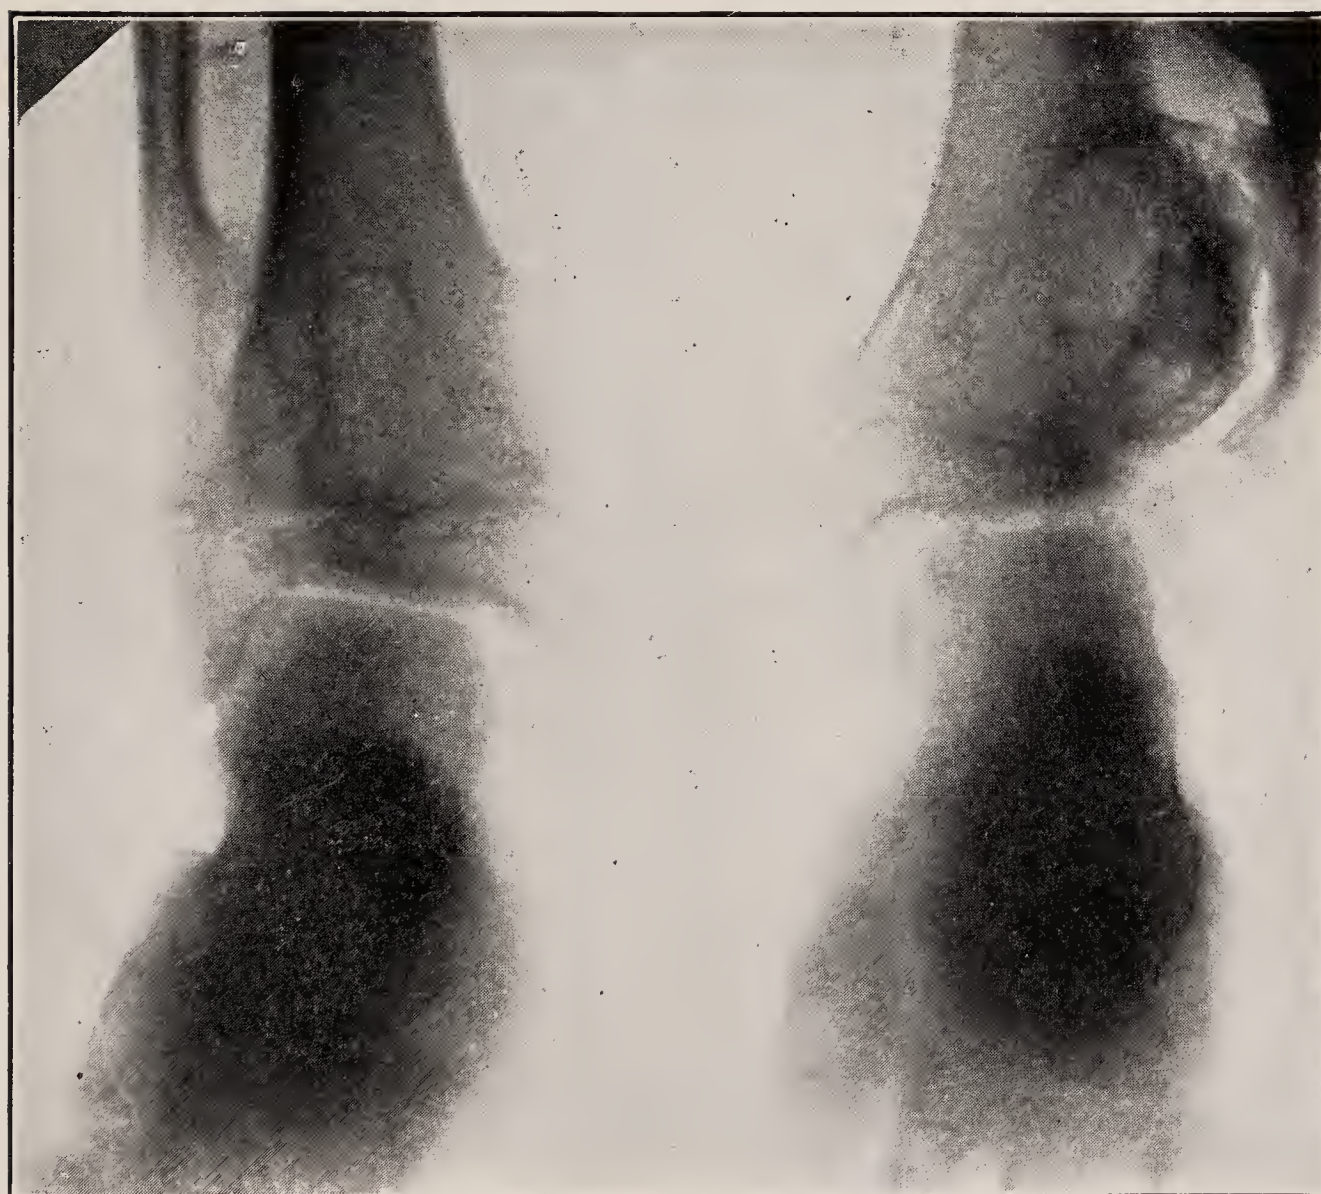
X-ray of dyschondroplasia of ankles.
